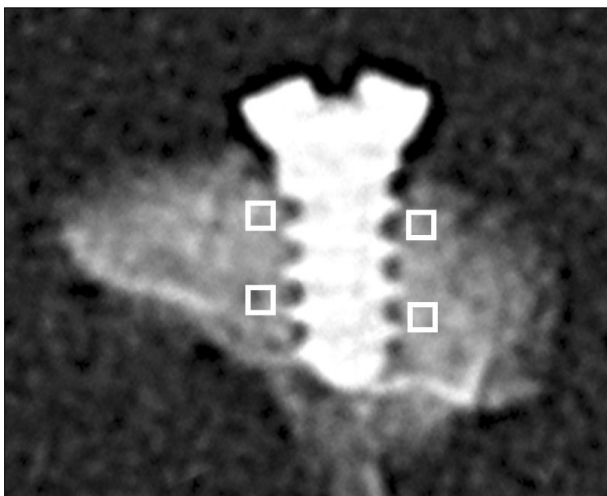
Example of X-rayed sample used for radiographic bone density measurements. White squares represent the 4 selected sites (two mesial and two distal).
